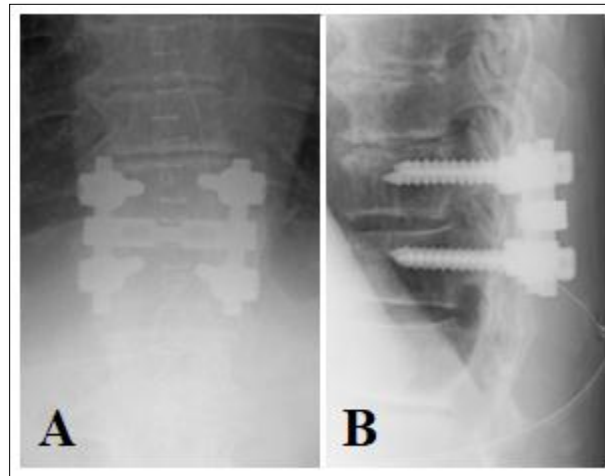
Postoperative plane radiograph decompression between T11 and T12 is evident. Posterior fixation was performed after decompression.
